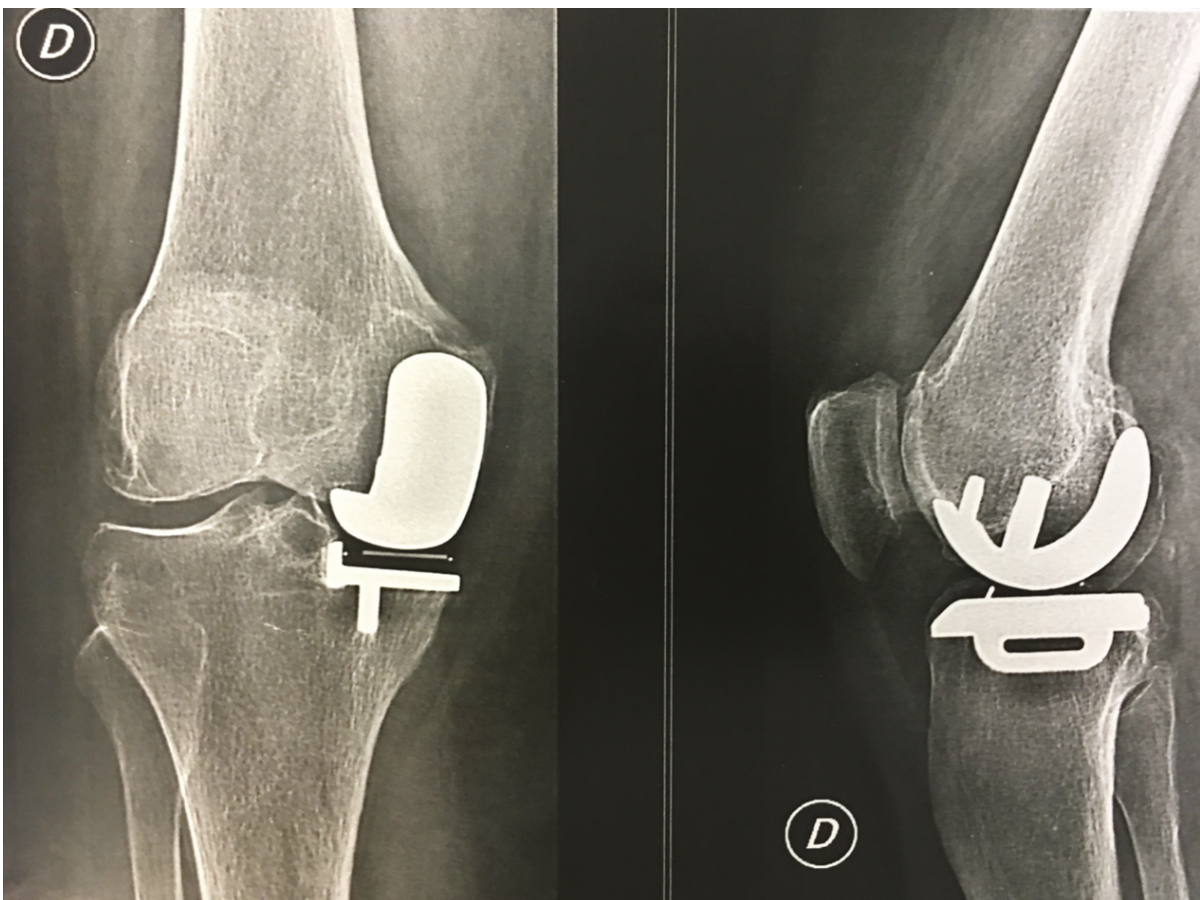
version 3 Oxford Knee X-rays.
